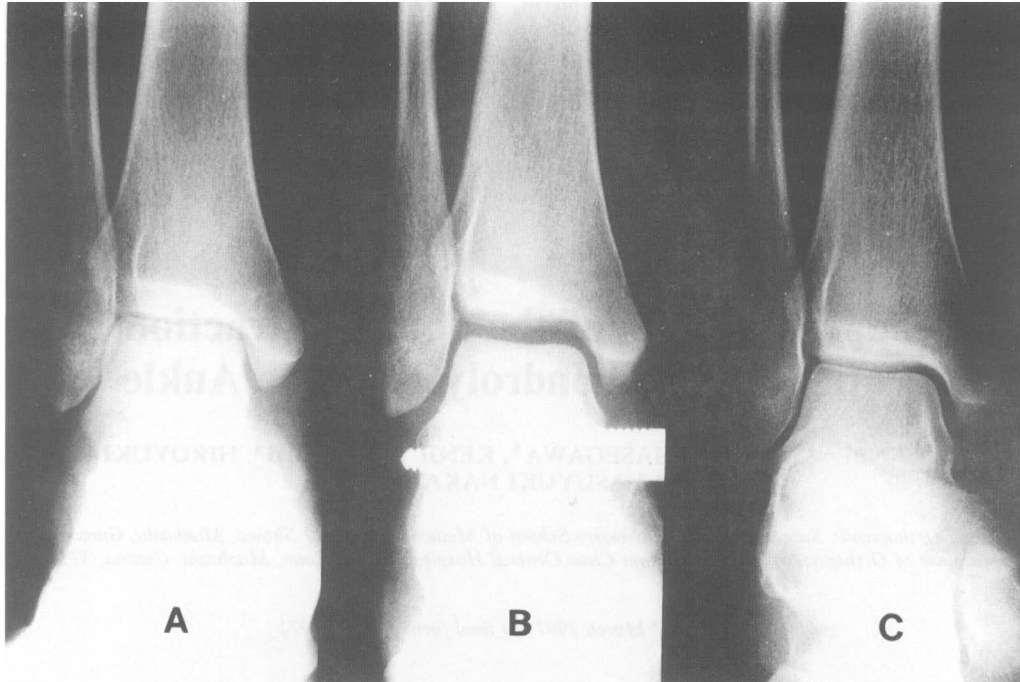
A: Preoperatively, the roentgenographic observations were those of slight osteoporosis and a decrease in cartilage thickness to 0.8 mm on the affected side as compared with 3.2 mm on the normal side; B: The joint space of the ankle was distracted to 5.0 mm; C: Twelve months after operation, joint space was 2.5 mm and osteoporosis was not recognized at the subchondral bone.
